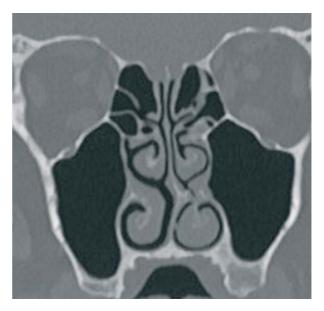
Coronal CT showing left deviated septum and septal spur in contact with the inferior turbinate.
